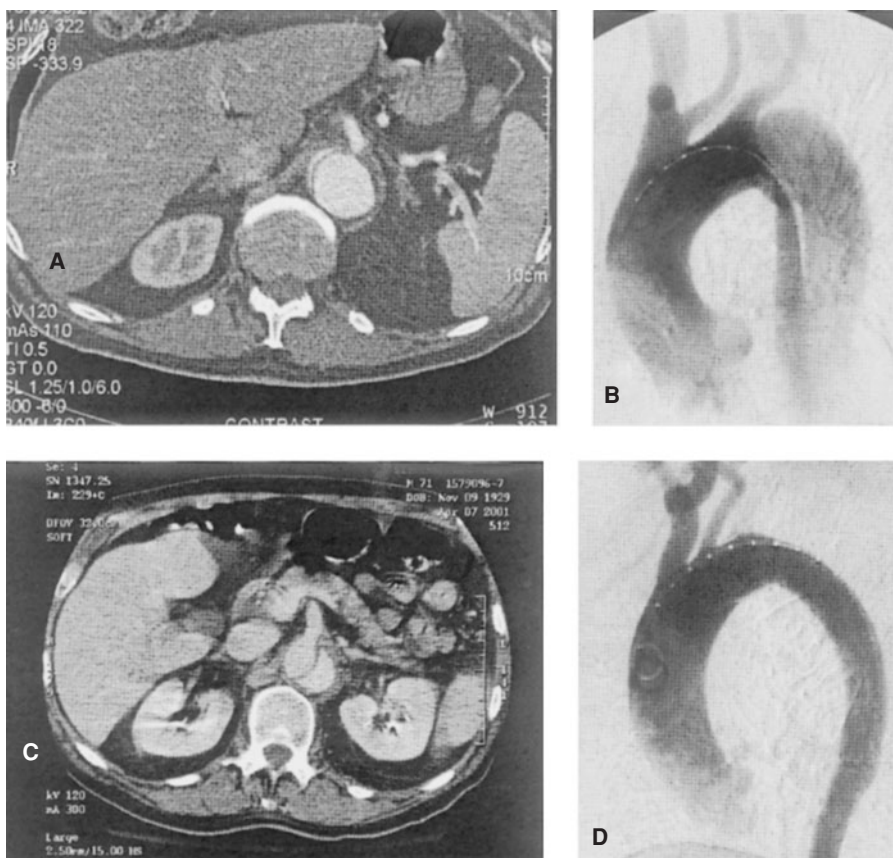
(A) Intravenous contrast-enhanced CT scan of the upper abdomen demonstrating an aortic dissection with compression of the true lumen. (B) Angiogram of the thoracic aorta demonstrating a type B dissection involving the descending thoracic aorta. (C) CT scan of the abdomen and (D) angiogram of the descending thoracic aorta after stent-graft implantation into the true lumen in the proximal descending thoracic aorta.
